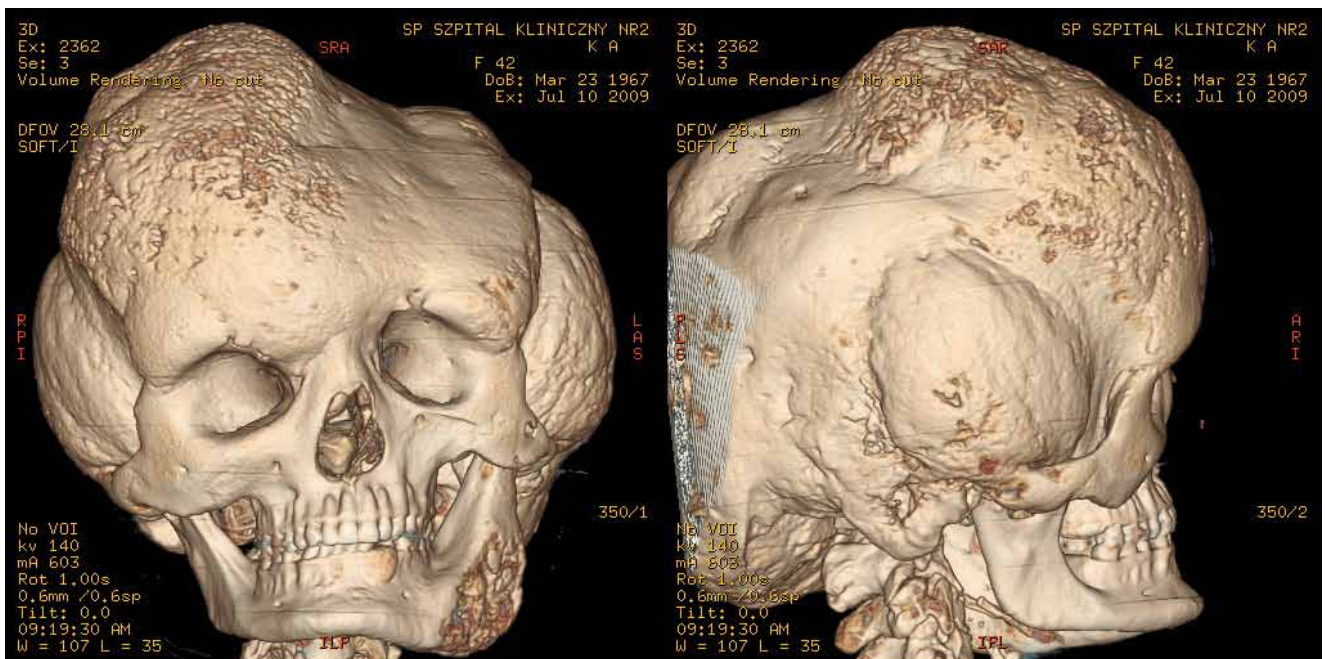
CT of the skull of the female patient K.A. aged 43 with the McCune-Albright syndrome and acromegaly.
